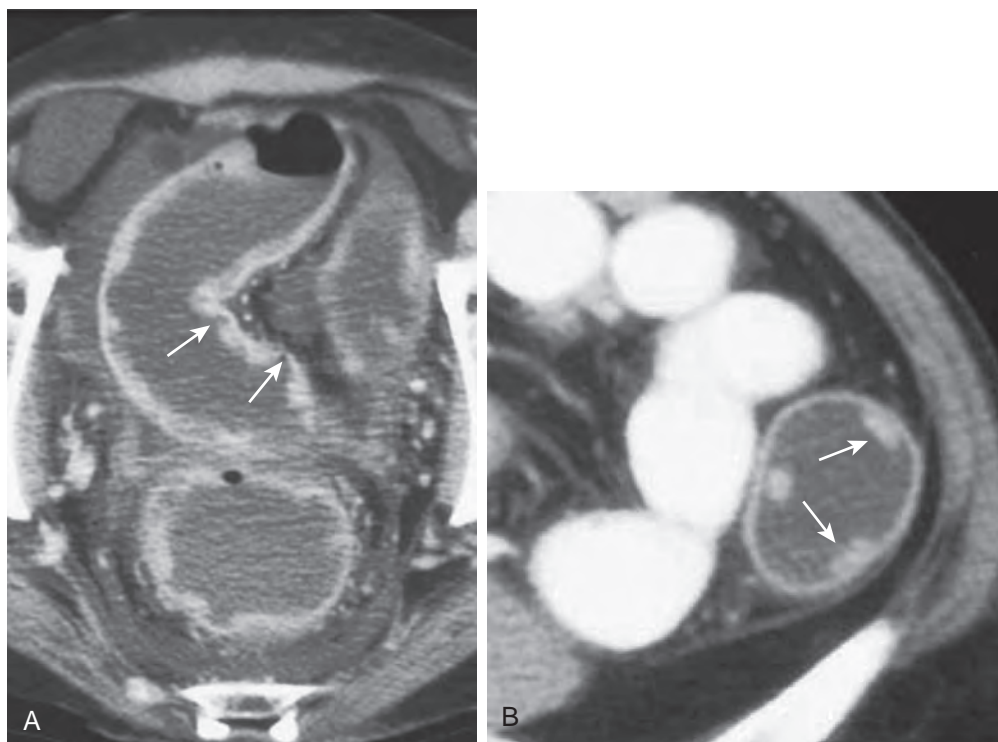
Mucosal disease in acute ulcerative colitis: CT features. A. Pelvic CT reveals diffuse mucosal thickening of fluid-filled rectum and sigmoid. Deep ulcerations (arrows) are visualized. Note normal lumen caliber and ascites. B. Magnified CT image of distal descending colon shows residual islands of inflamed mucosa protruding above the denuded colonic surface, so-called inflammatory pseudopolyps (arrows). (From Gore RM, Balthazar E, Ghahremani GG, et al: CT features of ulcerative colitis and Crohn's disease. *AJR* 167:3–15, 1996.)
